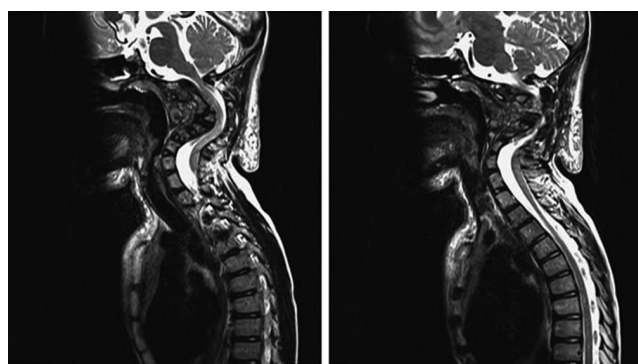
Sagittal slices of pre-operative magnetic resonance imaging showing the reduced size of the spinal canal in the upper cervical spine with insufficient posterior element bony detail (patient A).
